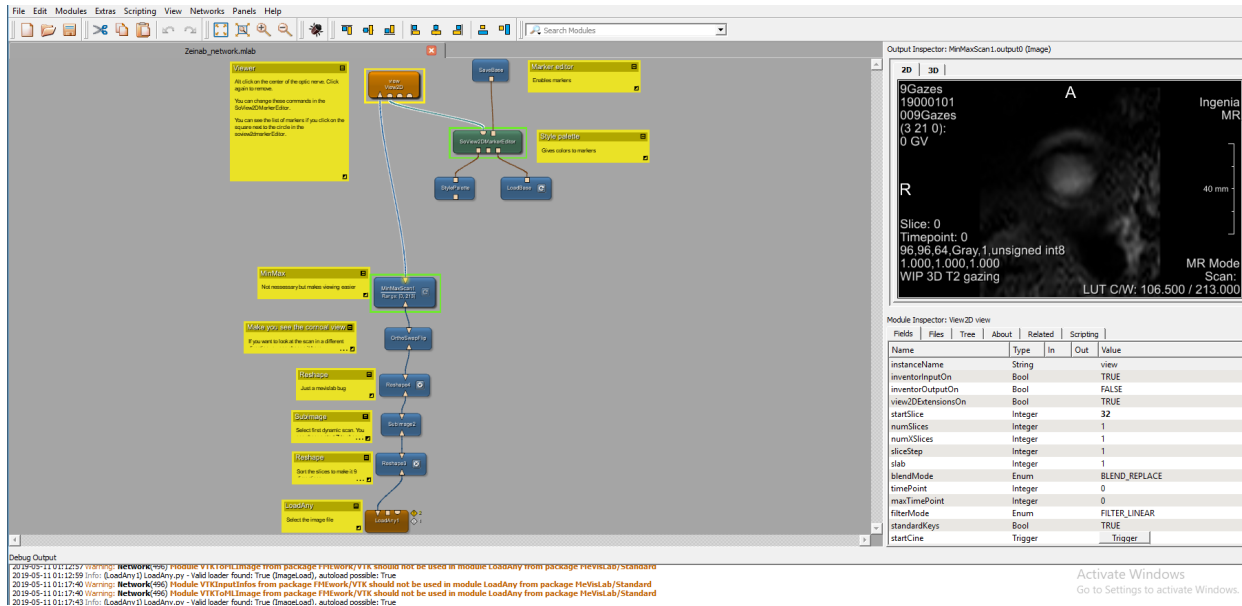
3T MRI images network for uveal melanoma patients - view2D.
